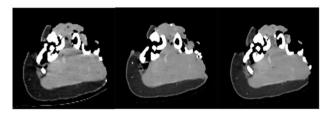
Comparison of images of the left leg reconstructed with fused CT and acquisitions at different energies: Respectively 80 KV (on the left), 120 KV (in the center) and fused CT (on the right).
